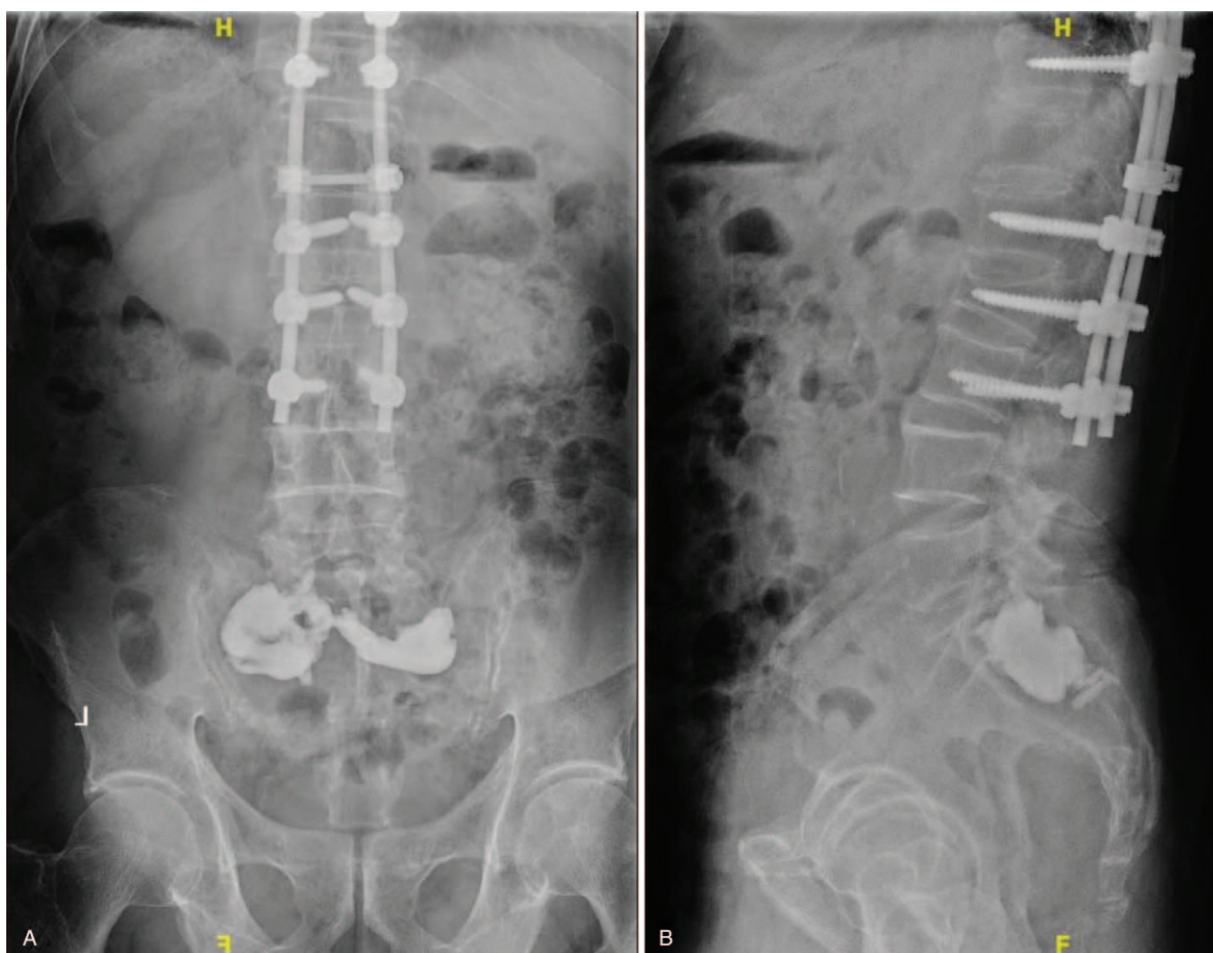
(A,B) PA and lateral x-ray image of the lumbosacral spine obtained postoperatively. PA=posteroanterior.
